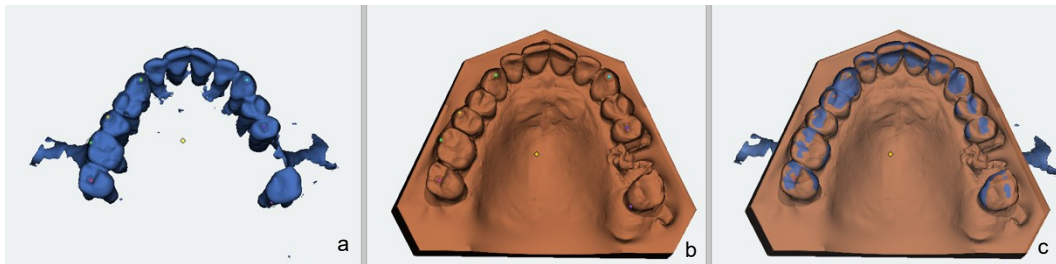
Superimposition based on corresponding surface points (green) a. CBCT dataset b. intraoral scan dataset c. fusion model of both datasets
